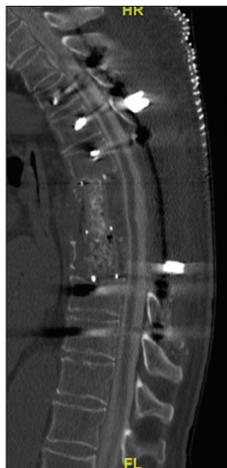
Postoperative computed tomography status post T6–8 corpectomy and T3–10 pedicle screw instrumentation. FL: Lower.
